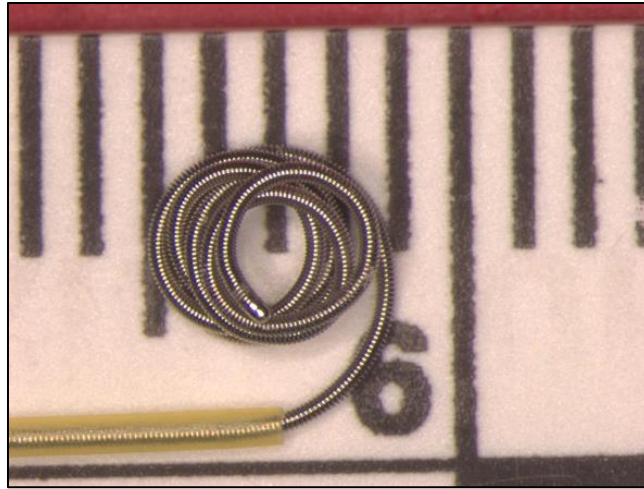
Image of a GDC® Ultrasoft detachable coil currently sold by Stryker Corporation. Each line on the scale in the background corresponds to 1 mm.
